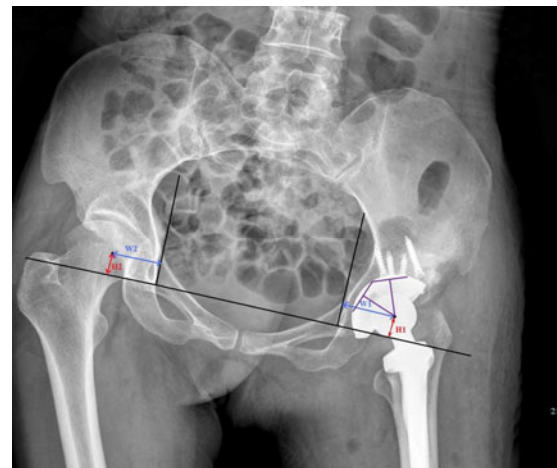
Measurement of the height of the hip center (H) and the horizontal location of the hip center (W) by postoperative radiographic analysis
